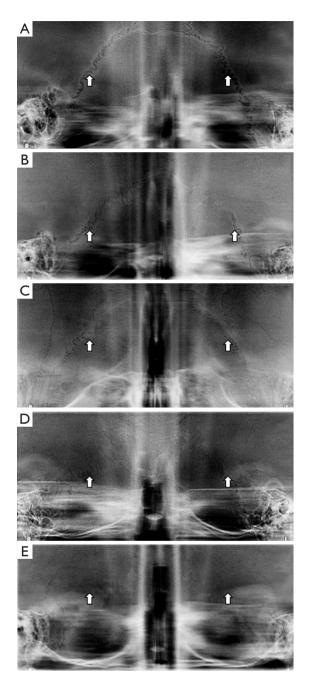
Frederic rating scale. (A) Score 0; (B) score 1; (C) score 2; (D) score 3; (E) score 4. (Radiographs from the present study).
